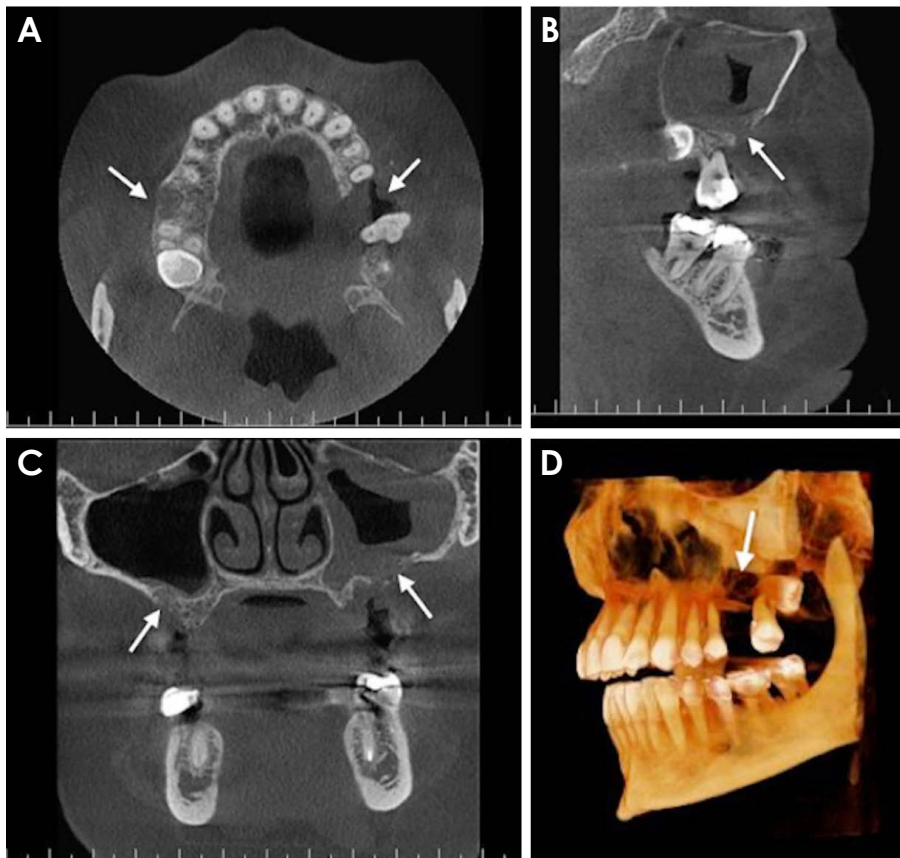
Multiplanar reformatted cone-beam computed tomographic images of a 63-year-old woman. A. An axial image shows loss of the buccal cortical plate in the right maxillary first molar extraction site (white arrow) and loss of both buccal and lingual cortical plates in the left maxillary first molar extraction site (white arrows). B. A sagittal image shows loss of cortication in the left maxillary sinus (white arrow). C. A coronal image shows the extraction sockets (white arrow). On the right side, note the loss of both the buccal cortical plate and floor of the maxillary sinus and the presence of mild mucosal thickening (white arrow) at the floor of the sinus. On the left side, note the loss of buccal and lingual cortical plates and circumferential soft tissue thickening of the maxillary sinus (white arrow). Calcified material (antrolith) can be noted in the left maxillary sinus. D. A volume-rendered image shows the loss of the cortical plate at the left maxillary first molar's extraction site (white arrow).
